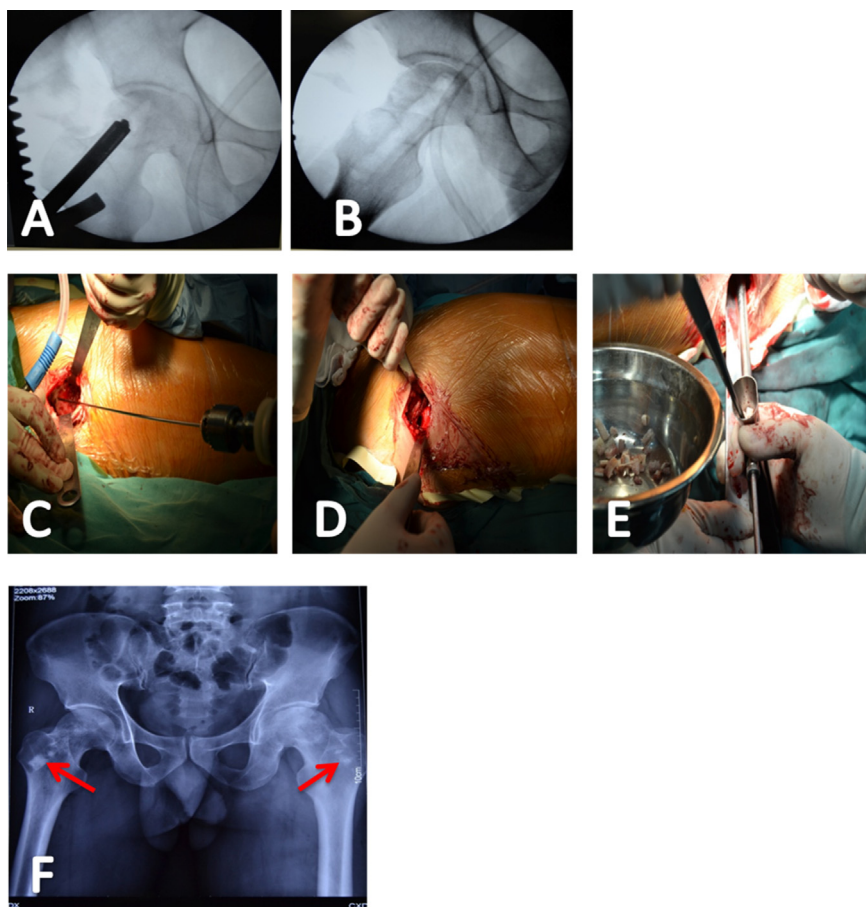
(A–E) The same patient as described in [Figure 1](#) treated using core decompression and allo-bone grafting. (F) The condition on the first postoperative day was delineated by dual X-ray absorptiometry; allo-bone implants were seen in the tunnel (red arrows).
